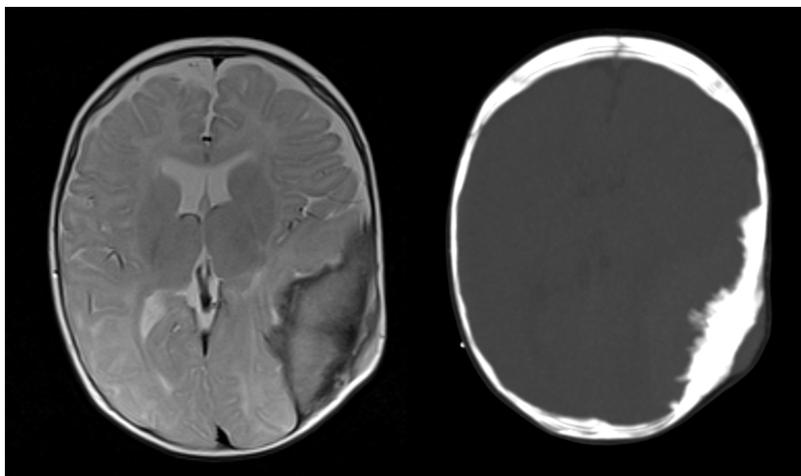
Computed tomography and magnetic resonance imaging demonstrating a melanotic neuroectodermal tumour of infancy presenting in the left occipital, temporal and parietal bone with marked spiculated periosteal reaction and extradural involvement of the left middle and posterior cranial fossae. Also noted is extensive temporoparietal lobe oedema adjacent to the lesion.
